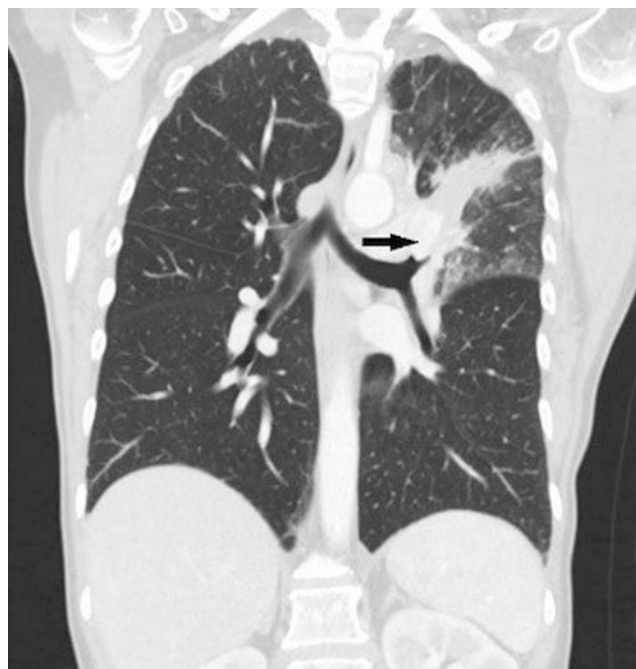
Features of carcinoid tumor in the coronal CT. Coronal CT shows a mass (*arrow*) intimately associated with bronchus, post-obstructive atelectasis, and pneumonia distal to the mass
